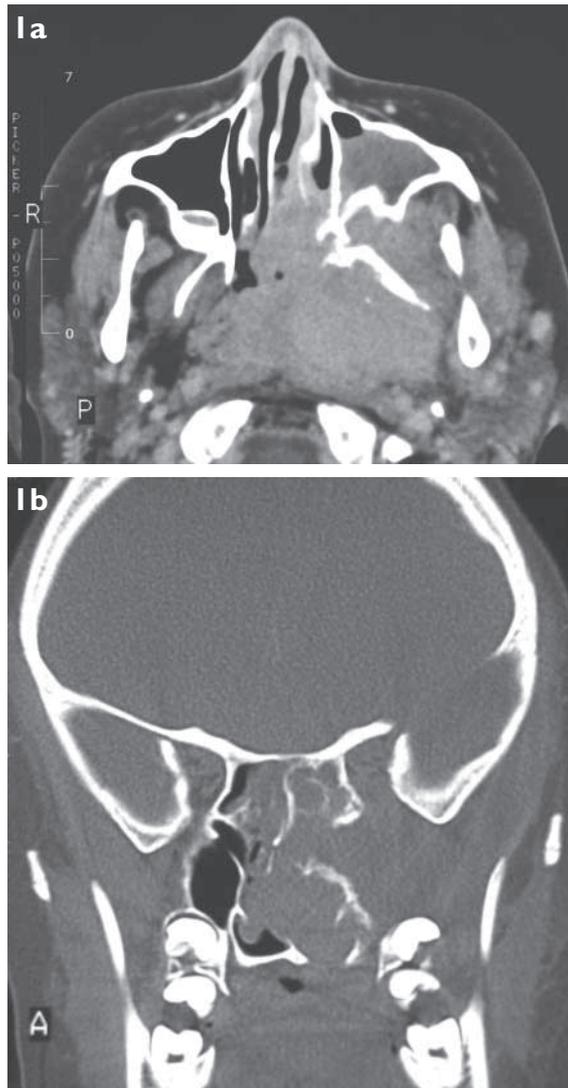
Enhanced axial (soft tissue window) and (b) coronal (bone window) CT scans of the nasopharynx.
